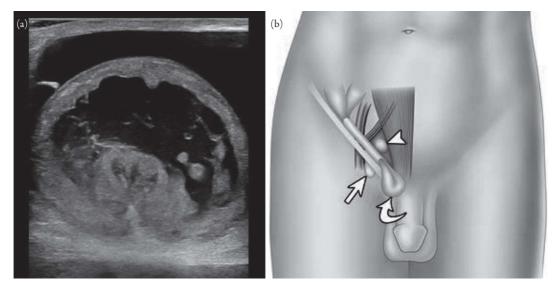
Incarcerated hernia with bowel wall thickening, echogenic fat, and free fluid. (b) Location of groin hernias. Direct inguinal hernias (arrowhead) originate in Hesselbach's triangle, which is bordered by the rectus muscle medially, inferior epigastric vessels superiorly, and inguinal ligament inferiorly. Indirect inguinal hernias (curved arrow) travel in the inguinal canal and are visualized in the scrotum. Femoral hernias (straight arrow) originate in the femoral canal just lateral and inferior to the inguinal ligament. Adapted from Figure 6 of Jacobson, JA, Khoury V, Brandon CJ. Ultrasound of the groin: techniques, pathology, and pitfalls. *AJR Am J Roentgenol*. 2015;205:513–523.
